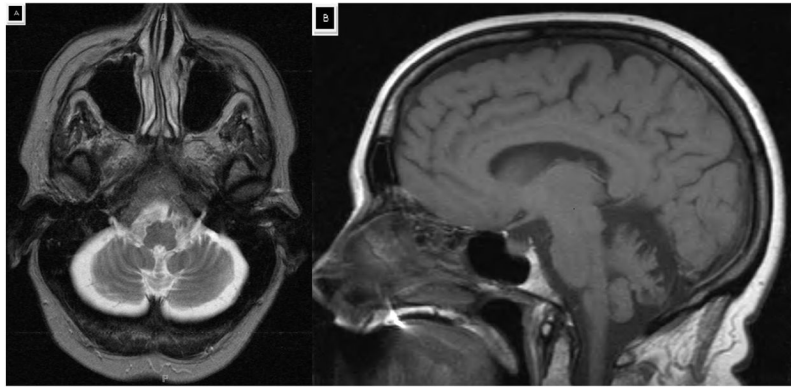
Axial T2-weighted image (A) and sagittal T1-weighted image (B) demonstrating cerebellar atrophy.
